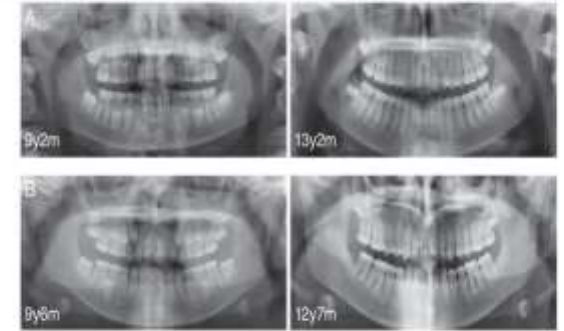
Dental orthopantomograms of two girls with XLH treated with conventional treatment (A) and burosumab (B). Note the enlarged pulp chambers, especially those of the first molars, and the improvement over time in both cases.
